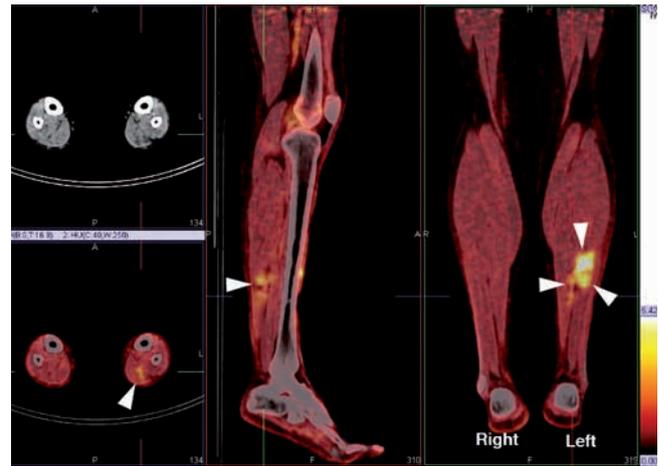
PET-CT. The focal lesion (white arrowheads) is FDG-avid with a Standard Uptake Value (SUV) of up to 5.0, indicating a metabolically active lesion.
